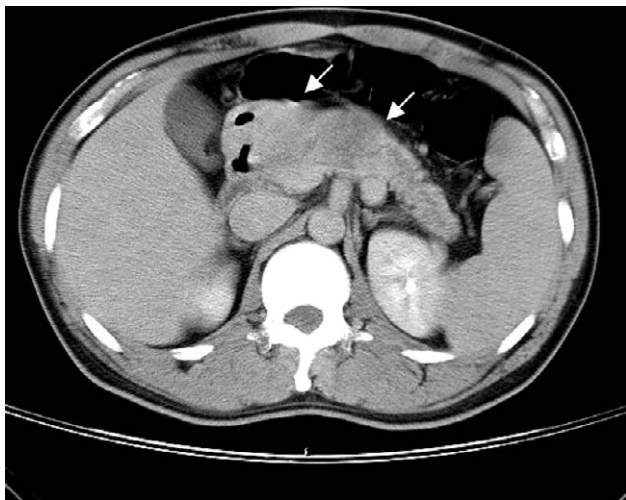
Computed tomography of the abdomen revealed a mass over the pancreatic head and body (arrows) with external compression on the superior mesenteric artery, the confluence of the splenic vein and the superior mesenteric vein, without evidence of peritoneal carcinomatosis or lymph node metastasis.
